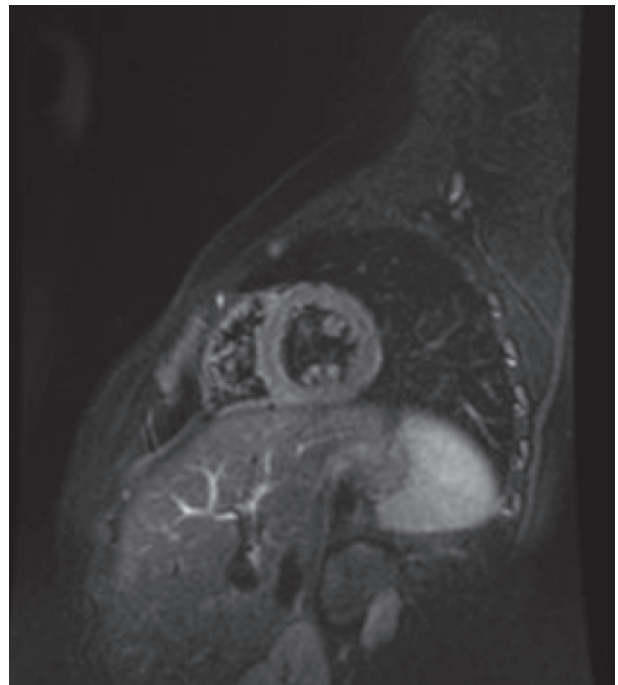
Cardiac magnetic resonance T2-weighted sequence. Slight left ventricular wall edema.
